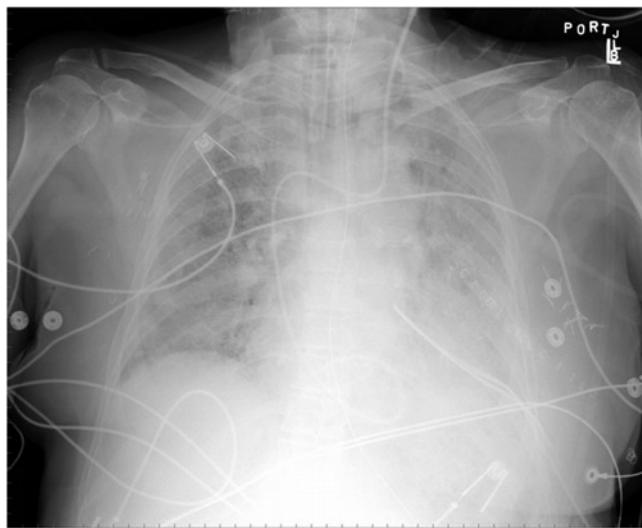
A patient with an acute lung injury (ALI) 72 h postoperatively, the interstitial edema has progressed in the chest X-radiograph. There is a single-lumen endotracheal tube in place; also a pulmonary artery catheter introduced via the left internal jugular vein is seen. The chest radiograph also shows bilateral diffuse fluffy opacities typical of interstitial pulmonary edema postlobectomy.
